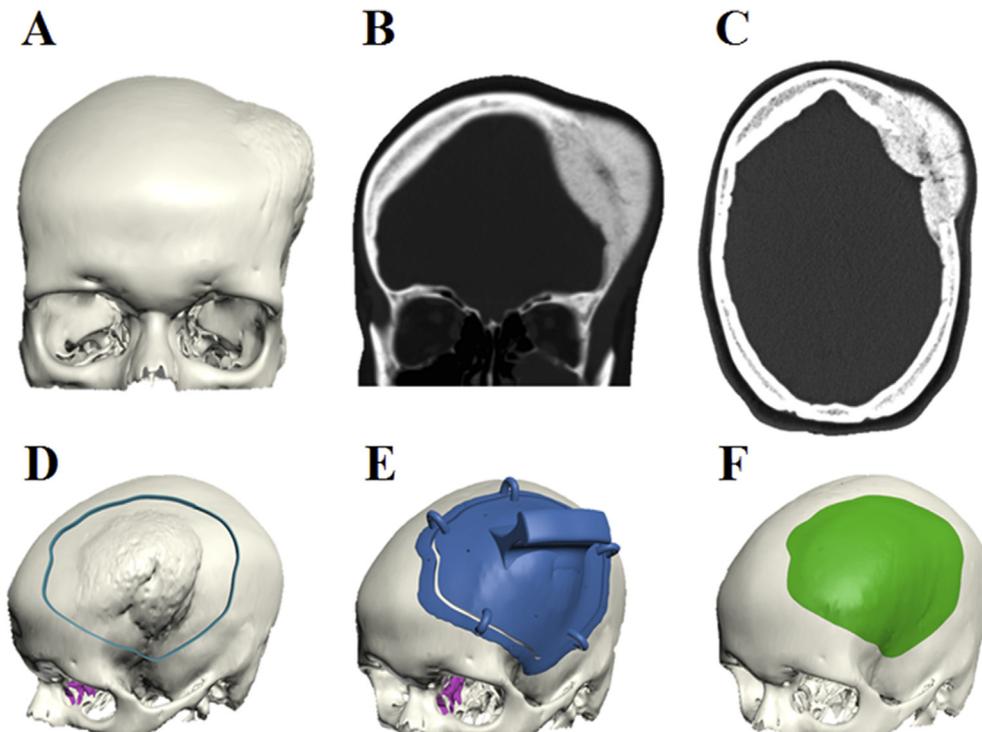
(A) 3D rendering of CT data. (B) CT coronal coupe. (C) CT axial slice. (D) Preoperative planned resection outline of the meningioma. (E) Nylon resection template. (F) Patient-specific implant designed using a mirroring technique.
